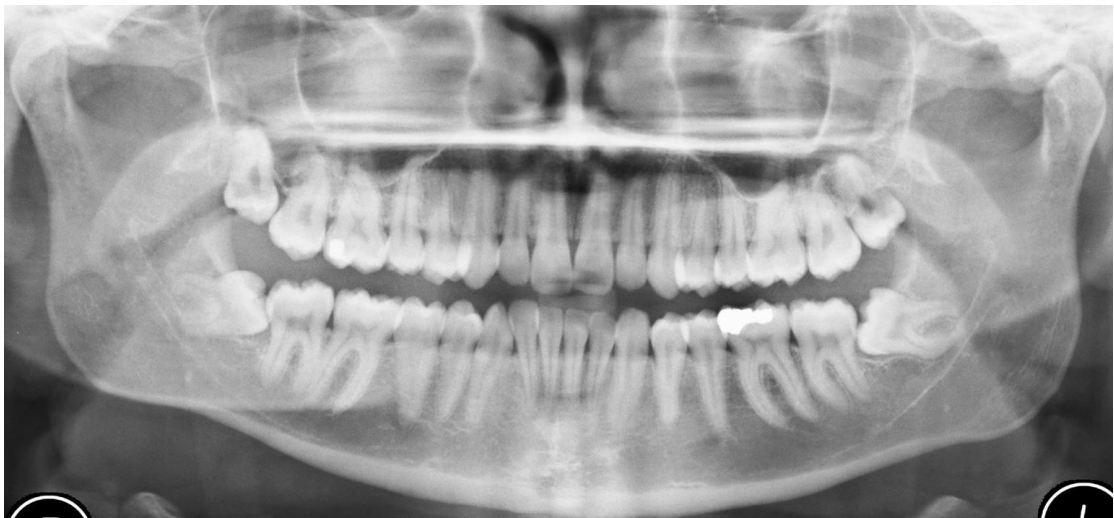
DPT radiograph showing one upper and two lower mesioangularly impacted third permanent molars
